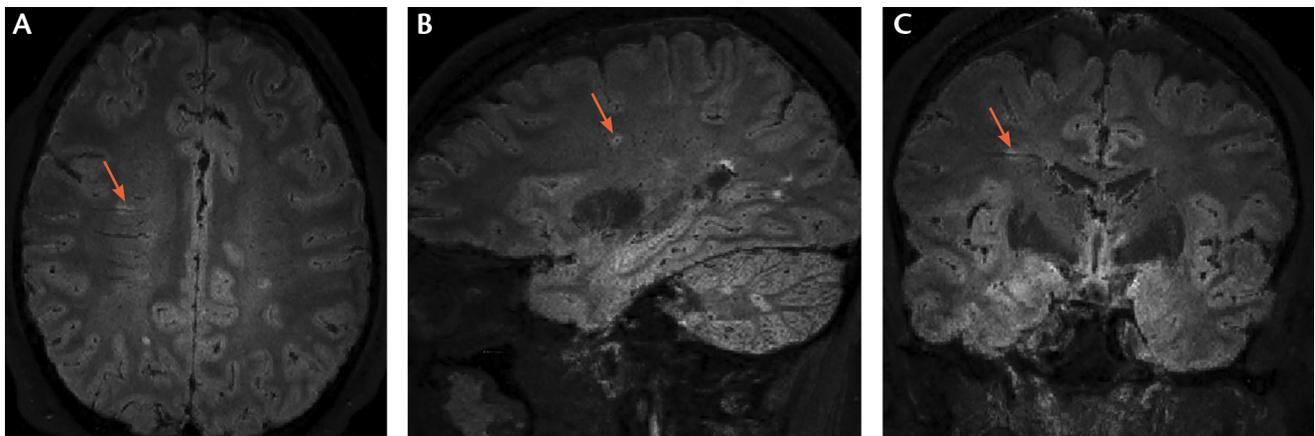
The central vein sign on fluid-attenuating inversion recovery* (FLAIR*) MRI.
